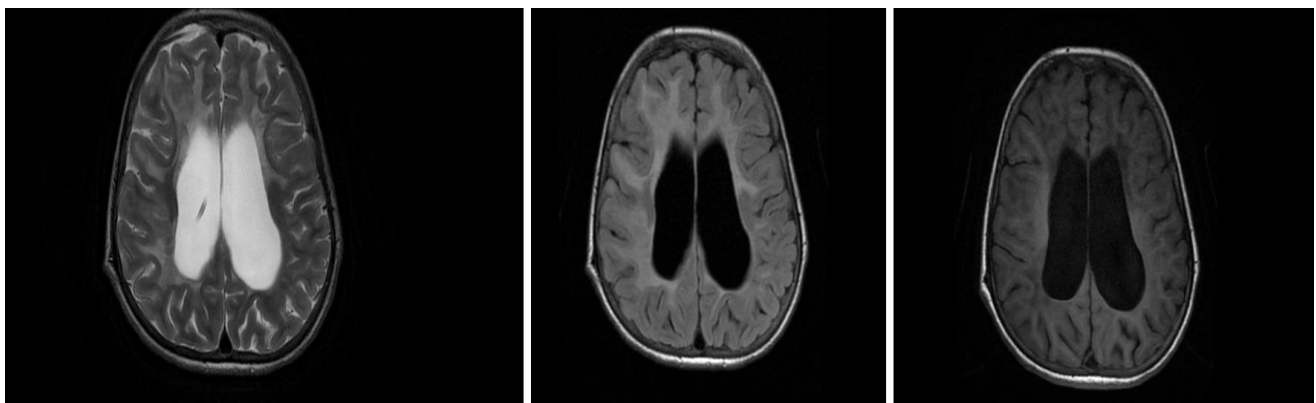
Axial MRI sequences. Left: T2-weighted image showing markedly enlarged lateral ventricles with bilateral periventricular white matter T2 hyperintensities. Middle: FLAIR image demonstrating dilated ventricles and confluent periventricular signal abnormality. Right: T1-weighted image showing bilateral T1 hypointensity in the periventricular and deep white matter corresponding to demyelination.
